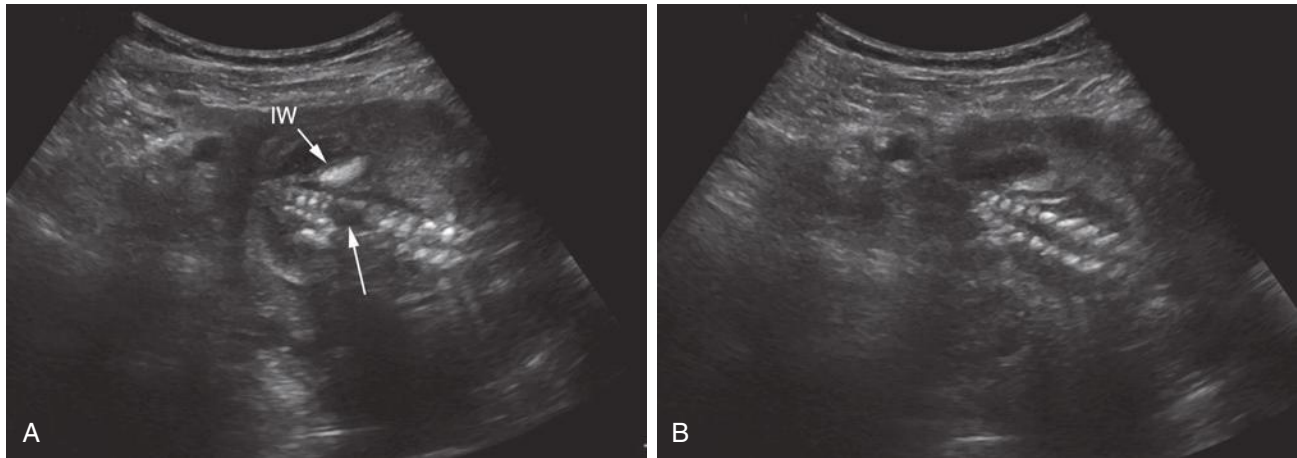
Apparent spinal defect. A, Coronal sonogram of the distal spine suggests absent spinal segments (*arrow*) as might be seen with spinal bifida. In fact, this appearance is due to shadowing from the overlying iliac wing (IW). B, With slightly different angulation and plane of section, the normal distal spine is better visualized and shown to be intact.
